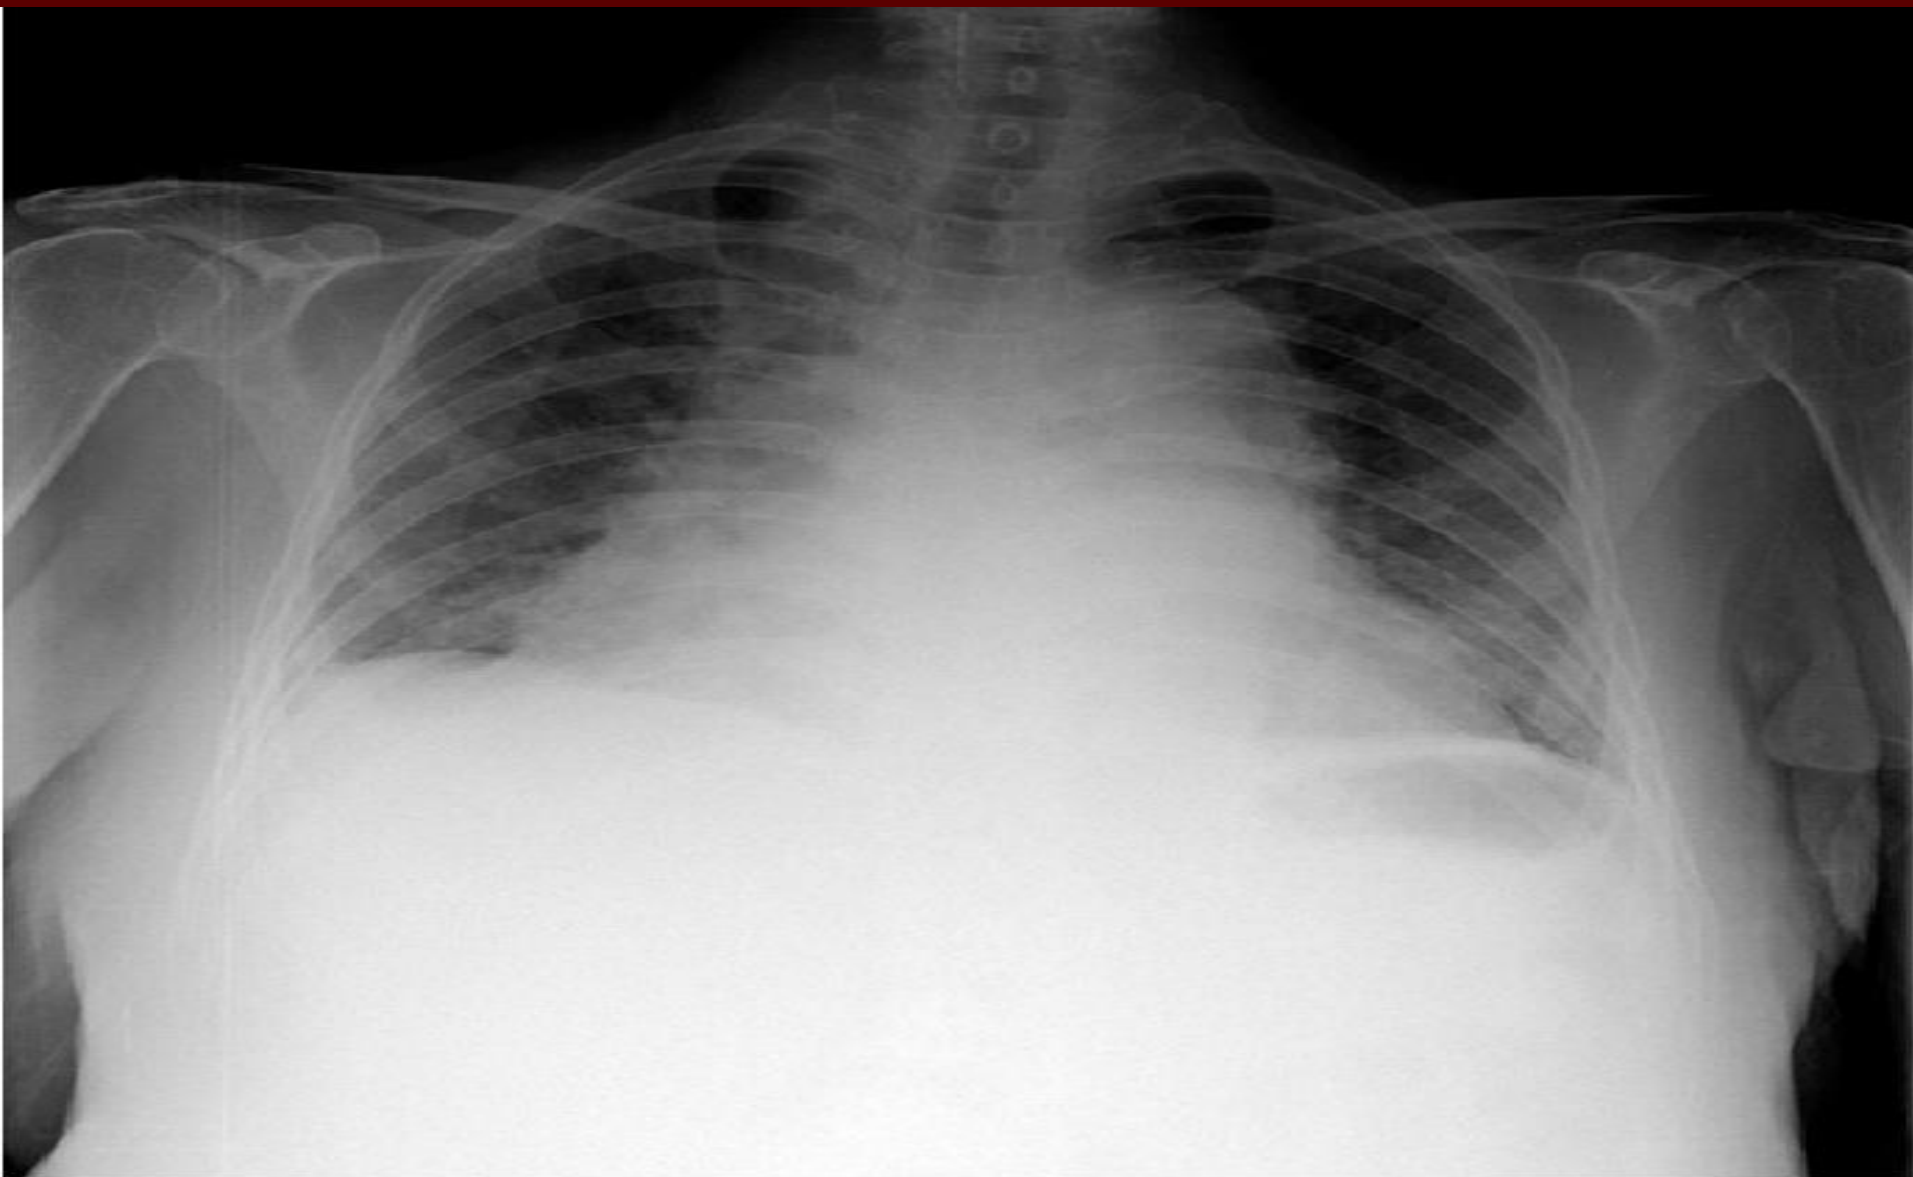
Chest radiography showing cardiomegaly with mild pulmonary
